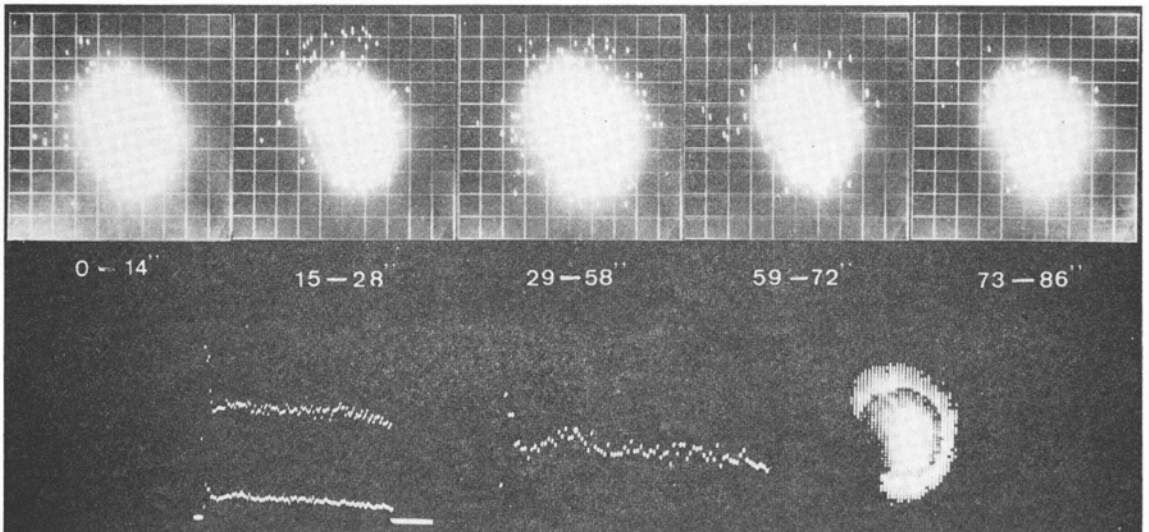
Serial scintigraphy replayed from the digital tape on the oscilloscope in a patients with normal kidney function after intra-arterial applied 2 mCi ^{131}I -o-Iodhippuric acid in 3.5 ml. Functional curves of the whole kidney and the renal cortex (left part) and the renal cortex alone (middle part), each signal corresponds to 2 sec. Regions of interest. Note that the first and the third area is bigger than the second and the fourth corresponding to the transport of the radioactivity through the different parts of the nephrons.
